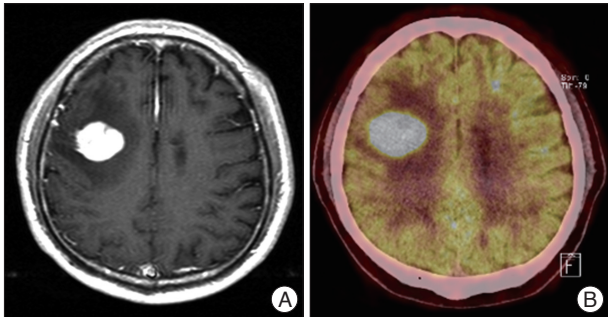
A : Gadolinium-enhanced T1-weighted magnetic resonance imaging showing a round homogeneously enhanced mass in the right frontal lobe with peritumoral edema. B : Positron emission tomography-computed tomography scan showing highly increased fludeoxyglucose uptake in the mass in the right frontal lobe.
